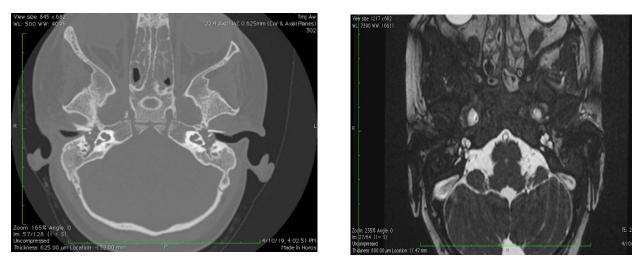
Left panel, CT scan of temporal bone; axial section. Right panel, MRI axial section 3D FIESTA. Both panels show bilateral incomplete partition type II
